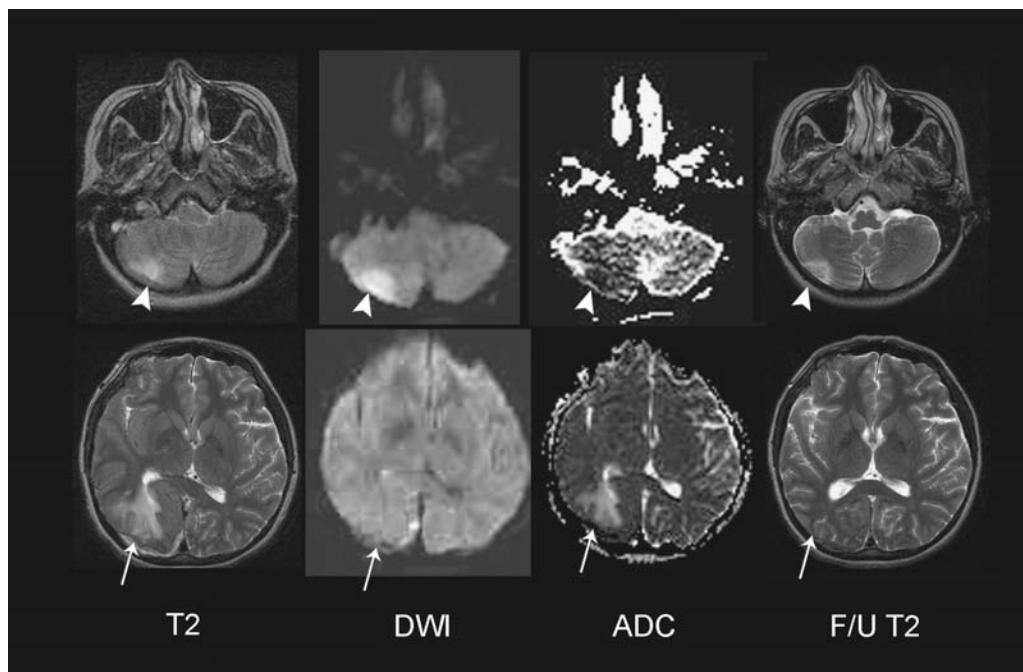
Cerebral venous sinus thrombosis with parenchymal lesions characterized by both vasogenic and cytotoxic edema. Thirty-one-year-old male with severe headache and vomiting. MR venogram (not shown) demonstrated thrombosis of the superior sagittal, right transverse, and right sigmoid sinuses. The T2 hyperintense right cerebellar lesion has decreased diffusion (DWI hyperintense and ADC hypointense), consistent with cytotoxic edema (arrowhead). The lesion is present at follow-up. The T2 hyperintense right parietal occipital lesion has elevated diffusion (DWI isointense, ADC hyperintense), consistent with vasogenic edema (white arrow). It is no longer present at follow-up. Abbreviations: DWI, diffusion-weighted images; ADC, apparent diffusion coefficient.
